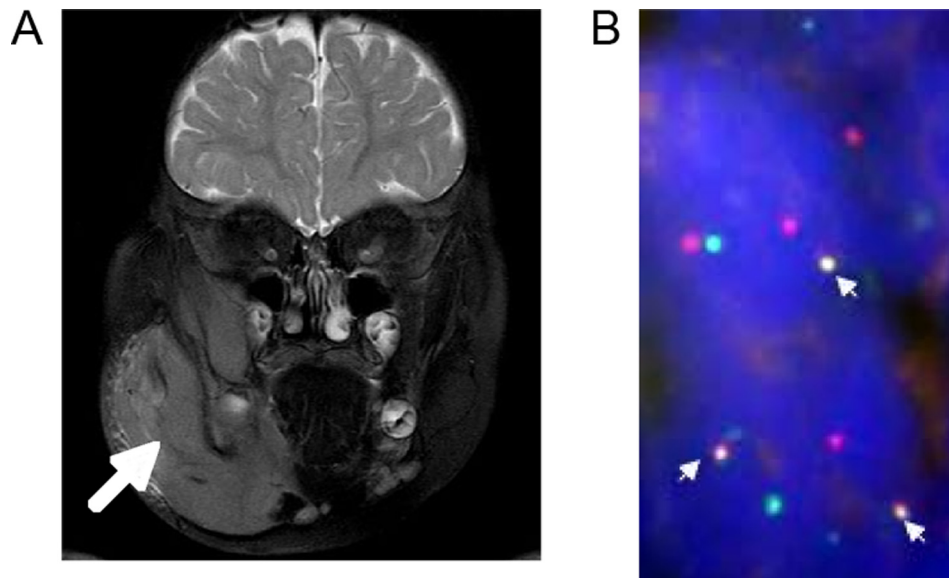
Infant's tumor. A Coronal T2-weighted MRI image of the right mandibular tumor. S1B FISH signal in paraffin-embedded section of jaw tumor biopsy. Dual color *BCR* and *ABL1* probes (Vysis) were used. *BCR-ABL1* fusion (yellow) arrowed shown in three cells. Cellular outlines (blue) are indistinct in this tissue section.
